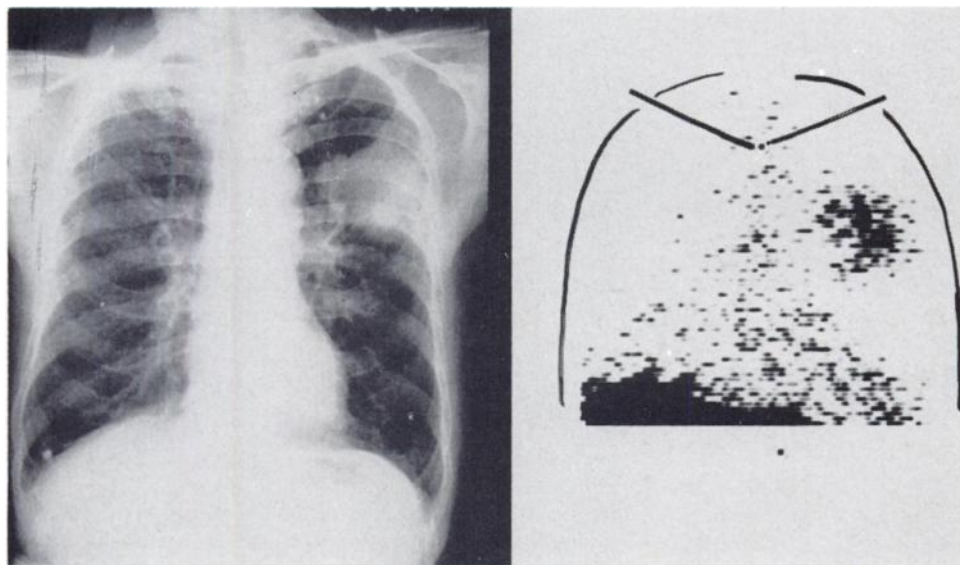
Left:* Roentgenogram of chest (PA) in a patient with squamous cell bronchogenic carcinoma, left upper lobe. *Right:* scan of chest (supine) 48 hours following the administration of ^{75}Se selenite ($300\ \mu\text{C}$) showing abnormal deposit of radioactivity in area corresponding to the tumor. Also note normal concentration of ^{75}Se in the liver.
